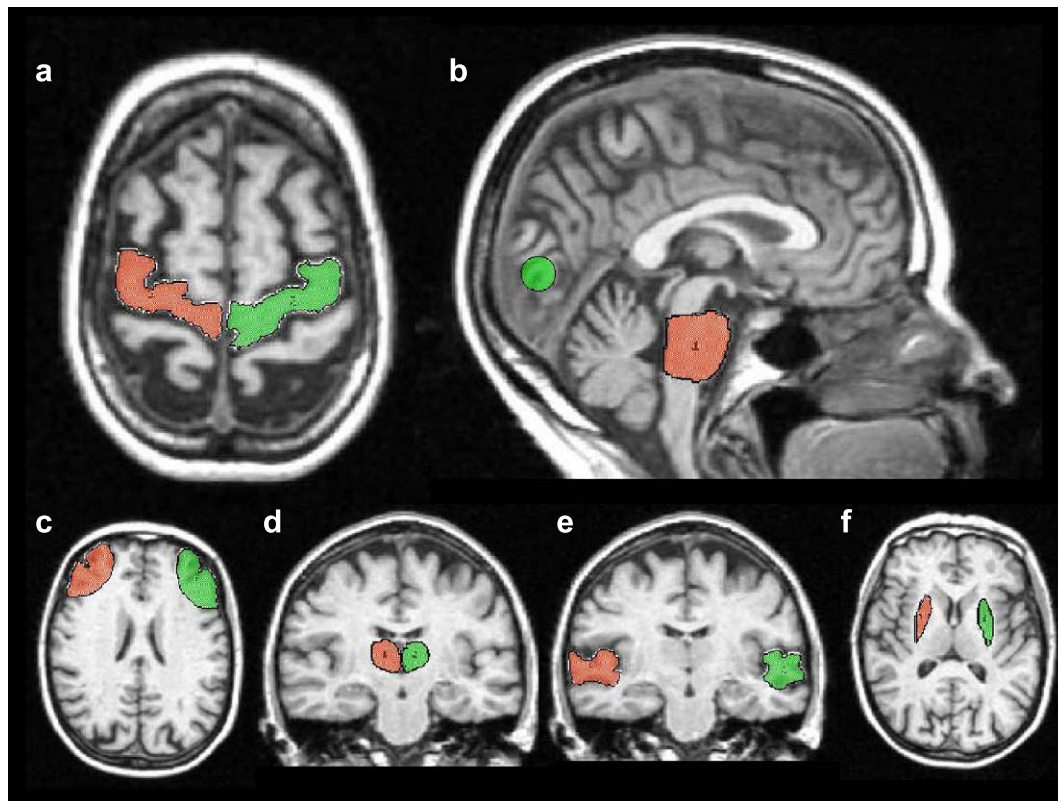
Volumes of interest (VOIs) drawn for each subject on individual T1-weighted MRIs in the absence of the PET images. The seven regions studied include motor cortex (pre-central gyrus) (a), pons and occipital lobes (b), frontal lobe (dorsolateral prefrontal cortex) (c), thalamus (d), superior temporal lobe (e) and putamen (f).
